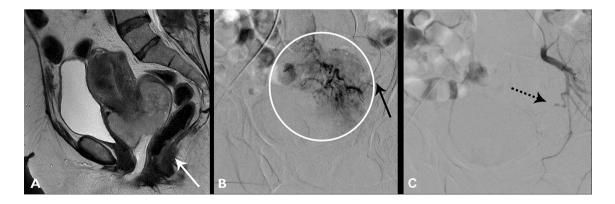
58-year-old patient hospitalized for metrorrhagia. a T2 sagittal MRI scan; voluminous cervical cancer mass involving vaginal fornix, not well defined from rectal wall (white arrow). b Diagnostic superselective DSA through a 2.7Fr microcatheter (black straight arrow)
